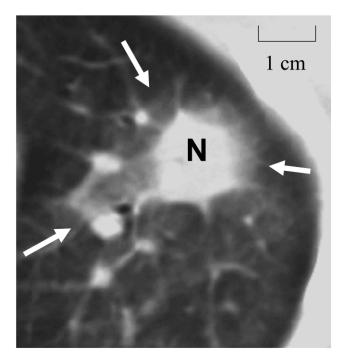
Computed tomographic section through the lung, demonstrating a halo sign in a patient with hematological malignancy. The sign consists of 2 parts: a solid nodular core (N), through which no pulmonary parenchyma is visible, and a ground-glass perimeter of intermediate density *(arrows)*, through which pulmonary parenchyma is still visible. Note that the nodule is >1 cm in diameter and that the area of ground-glass opacity surrounds more than three-quarters of the nodule.
